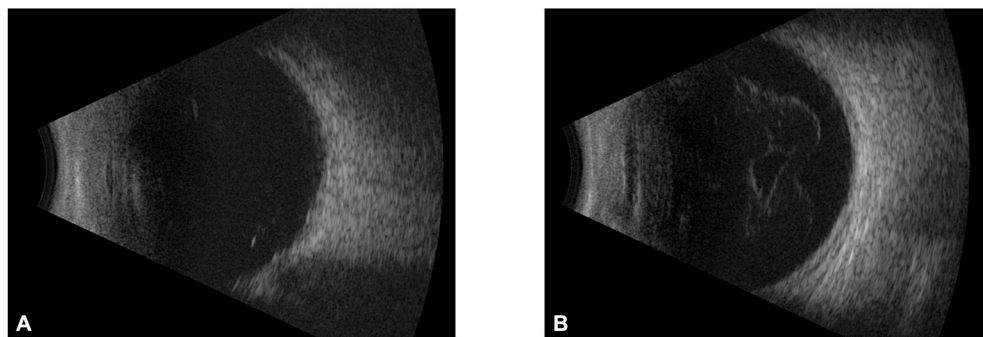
(A) B scan ultrasonography performed when the patient developed a new hypopyon revealed no vitreous debris. (B) Following his first therapeutic penetrating keratoplasty, serial B scans demonstrates worsening vitreous debris concerning for endophthalmitis.
